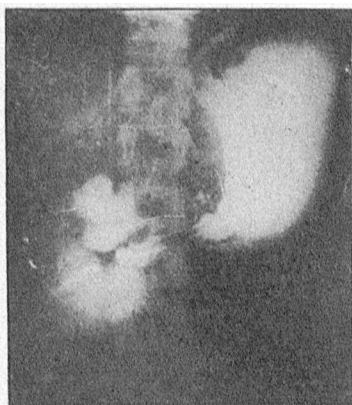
No. 6040. X-ray plate showing dilatation of duodenum.
